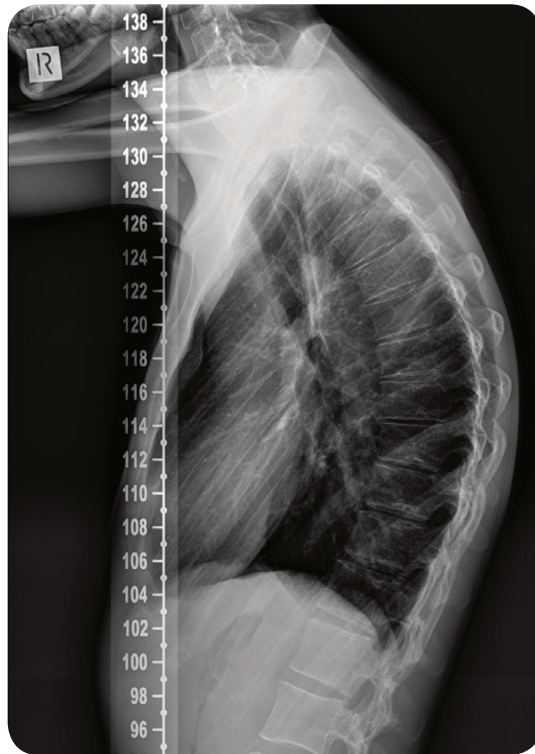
A lateral X-ray image of the spine demonstrating marked thoracic kyphosis secondary to Scheuermann's disease.
